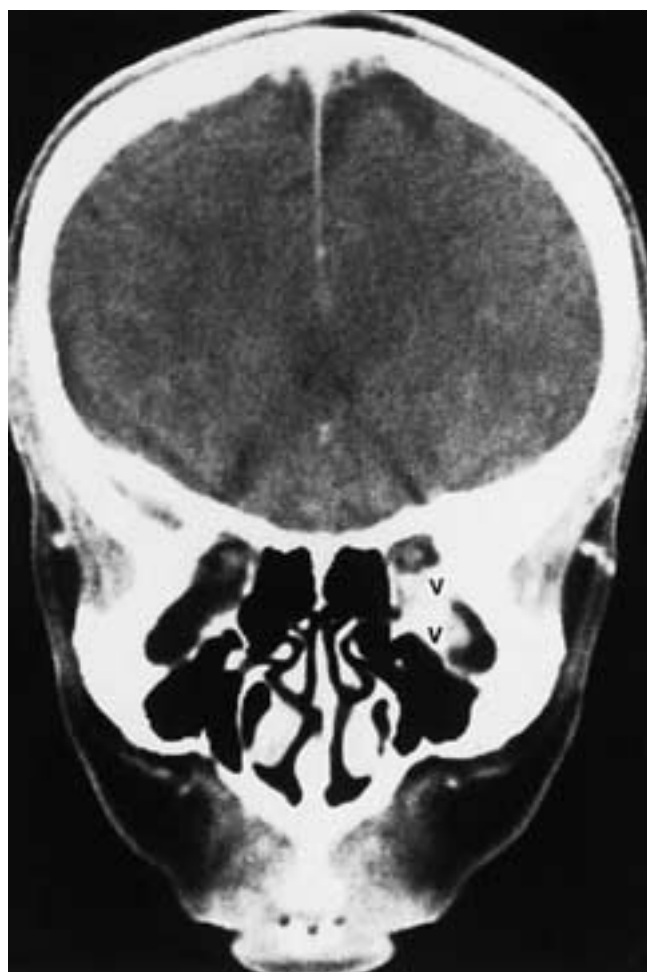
Orbital varix. Coronal contrast-enhanced CT scan shows several round, enhancing masses compatible with orbital varix (V).
